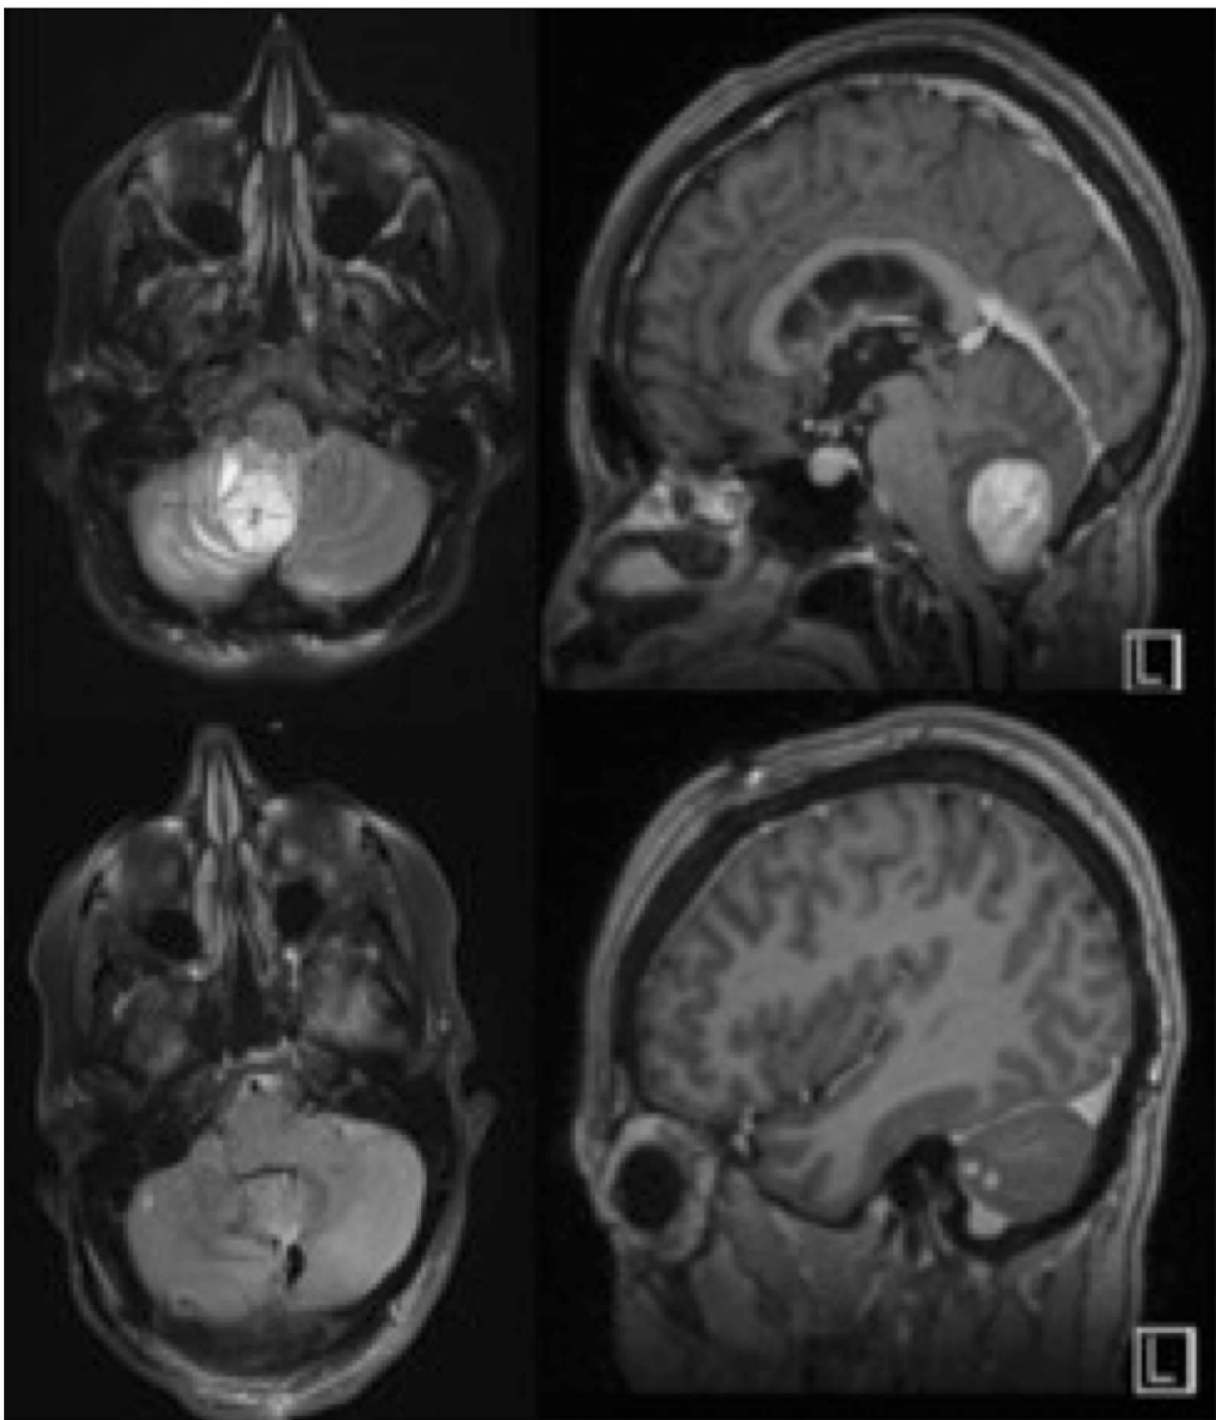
MRI images pre- and post-resection.
